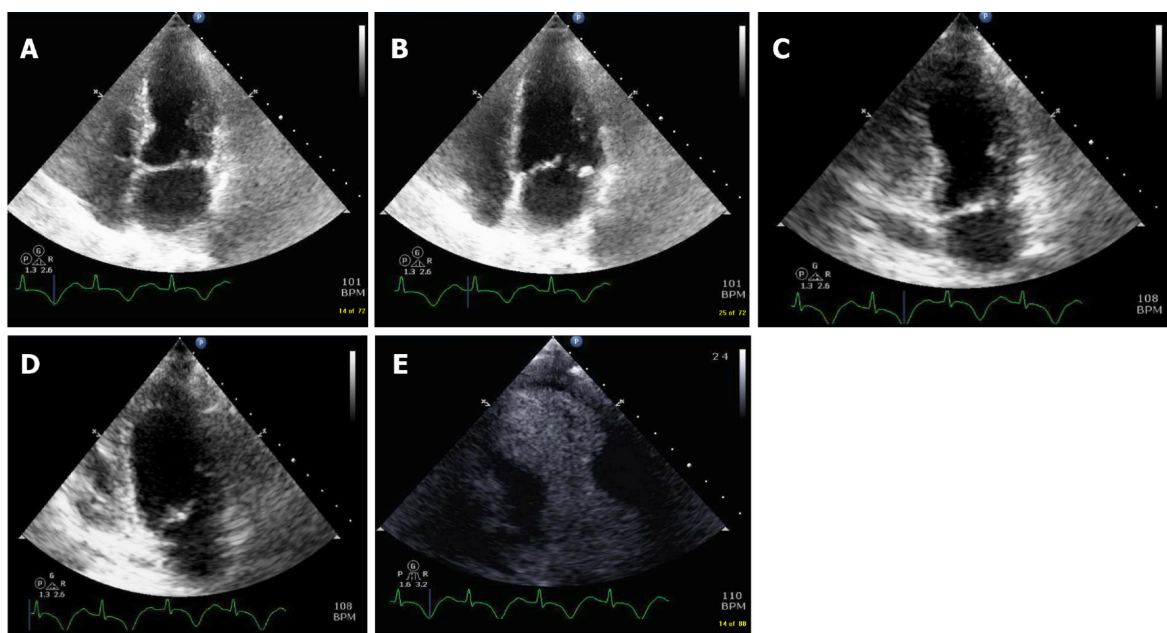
Four and 2 chamber view. A: 4 chamber view demonstrating akinesis of the septal and lateral apical segments; B: 4 chamber view demonstrating akinesis of the septal and lateral apical segments; C: 2-chamber view showing akinesis of anterior-inferior apical segments during systole; D: 2-chamber view showing akinesis of anterior and inferior apical segments during diastole; E: Contrast echocardiography showing akinesis of anterior and inferior apical segments.
